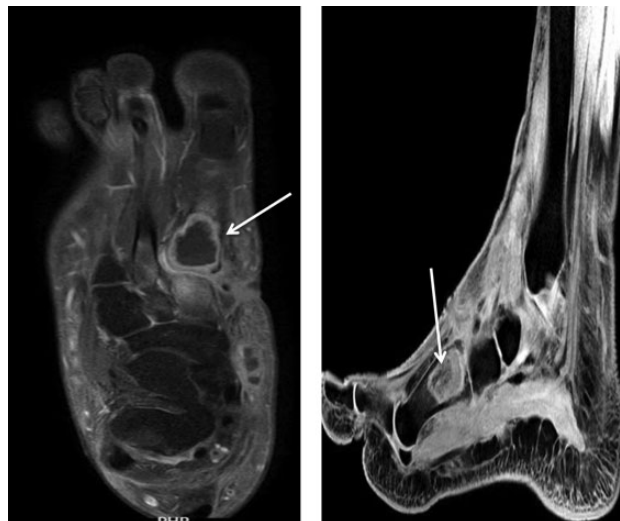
MRI scans: axial and sagittal views. T<sub>2</sub>-weighted images (white arrows pointing the site of lesion).
